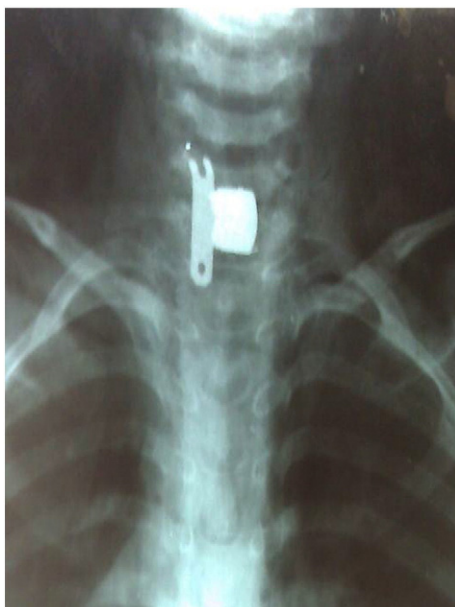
X-ray of the neck showing impacted metal foreign body in cervical esophagus.
